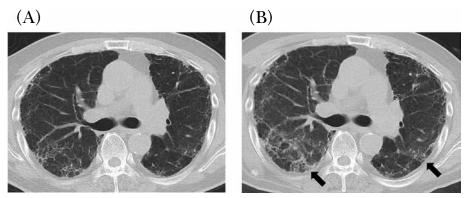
Chest computed tomography scan two weeks before the patient was hospitalized (A) and on admission (B).
